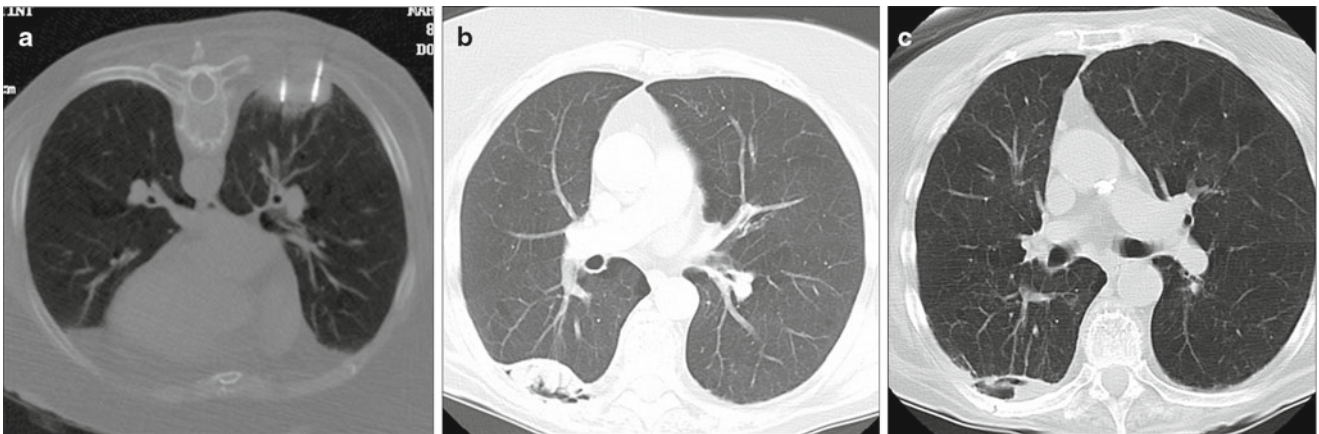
An 85-year-old woman with 5-cm right lower lobe non-small cell lung cancer was referred for microwave ablation due to poor performance status and dementia. (a) Prone axial CT fluoroscopy image shows two of the four microwave antennae used to treat this cancer.
